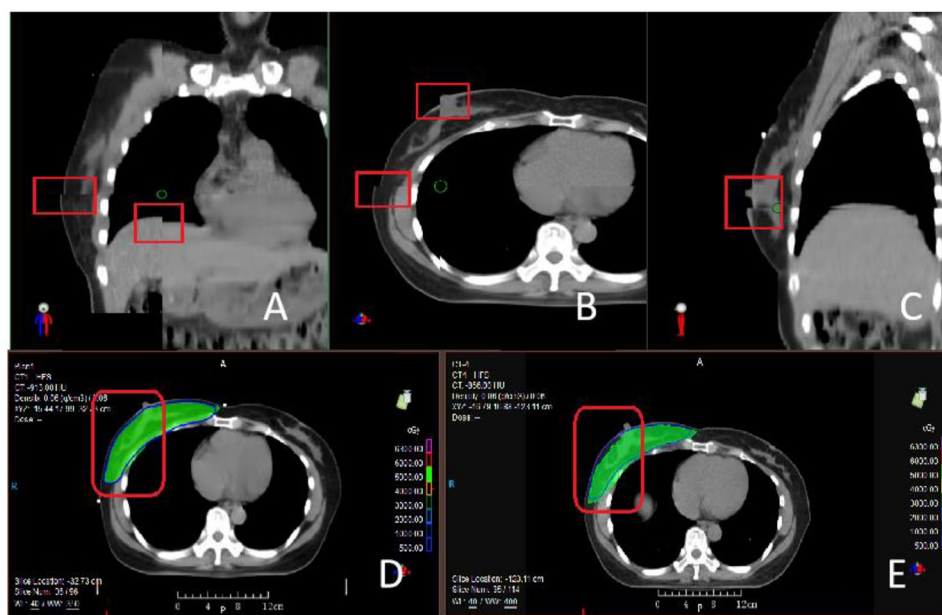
For right breast cancer, the top row of images shows the positional deviation of the FBCT image and CT image fusion in coronal (A), transverse (B), and sagittal (C) planes on the same day, respectively
